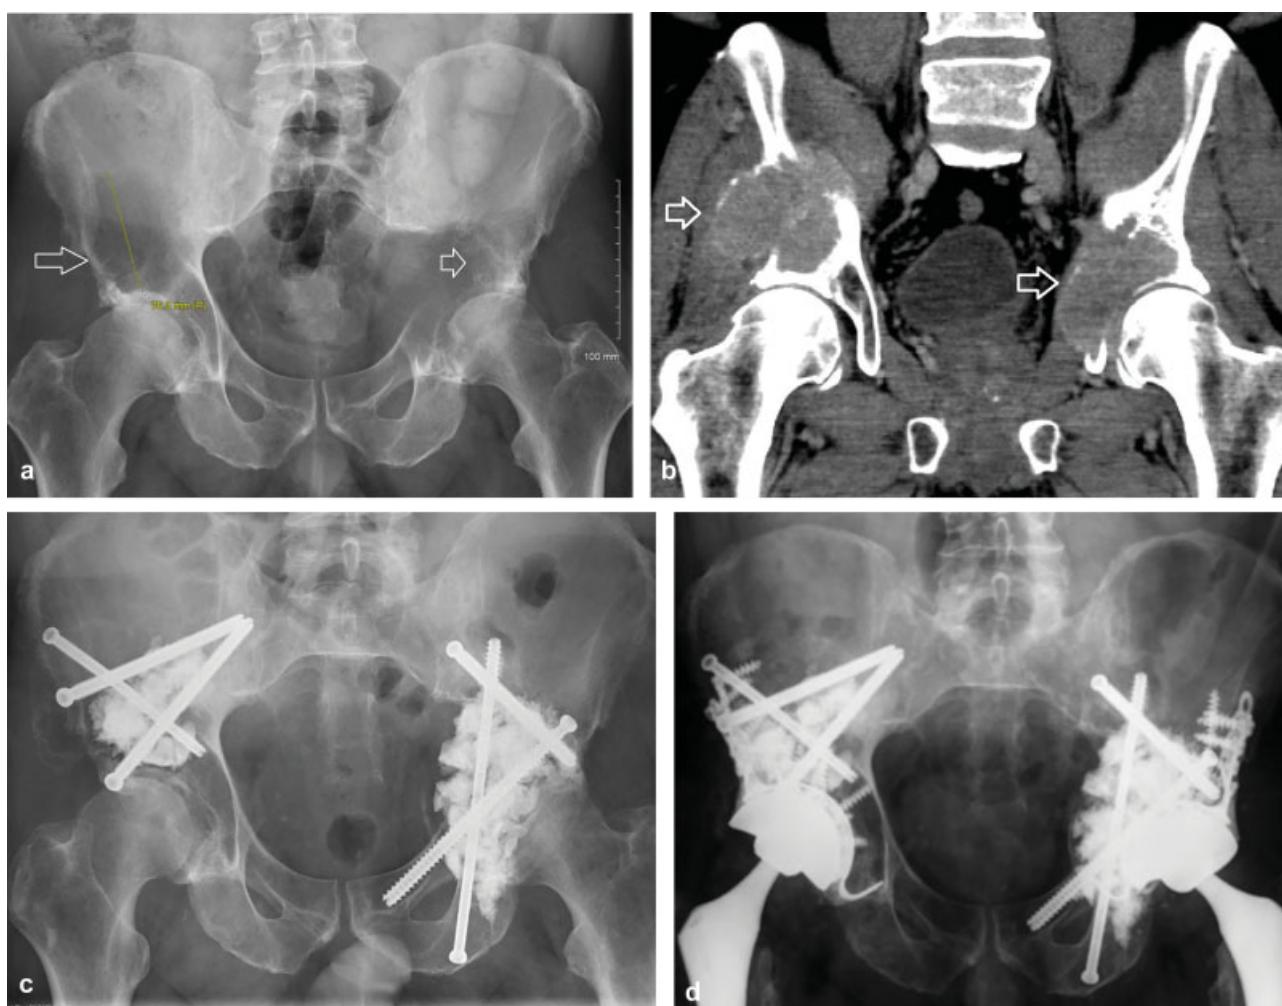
A 63-year-old man with initial presentation of progressive left hip pain. Pelvic radiograph (a) and CT (b) showing bilateral destructive acetabular lesions (white arrows). (c) Status post bilateral acetabular percutaneous ablation and “screw and glue” fixation procedures. Each side was performed 7 days apart. Patient was ambulating with a walker on postoperative day 1. Adjuvant systemic and radiation therapy were both initiated within the week after stabilization. Unfortunately, despite initial pain relief, he developed bilateral hip pain 6 months after minimally invasive stabilization due to fragmentation of his acetabular rim and rapid joint degeneration bilaterally. He underwent sequential total hip arthroplasty with an end result similar to a Harrington type procedure (d), with good postoperative pain relief. The previous screws and cement were described at the time of surgery as facilitating rather than hindering surgical repair.
